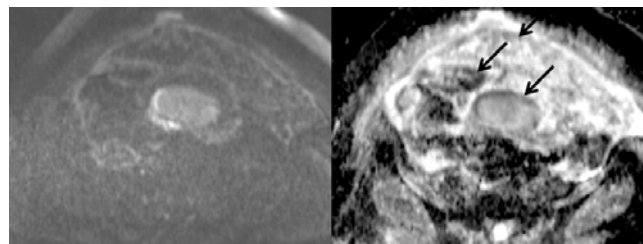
On diffusion weighted magnetic resonance images and apparent diffusion coefficient maps, there is the restricted diffusion as a pitfall.
